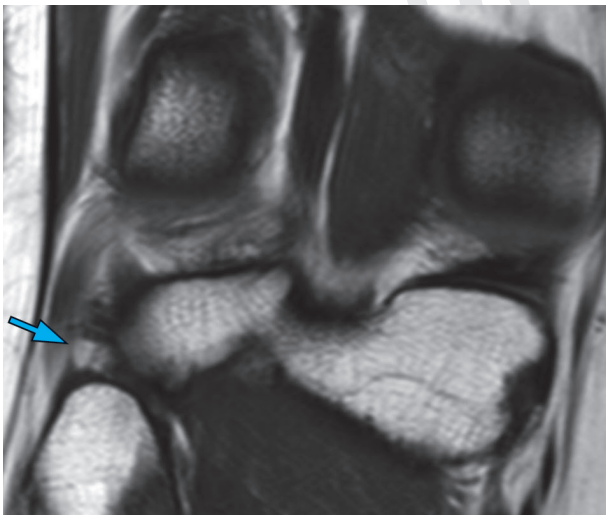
The typical Y-shaped arcuate ligament is clearly seen on this coronal T1-weighted image (arrow).
